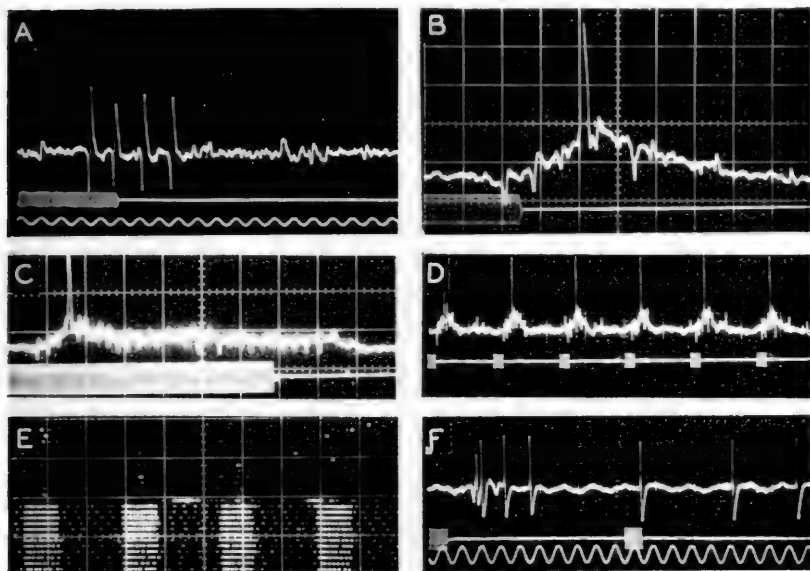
Responses to stimulation of the tympanic organ recorded with micro-electrode from sensory and interneurons in the pterothoracic ganglion of noctuid moths (*Caenurgina erechtea* and *Heliothis zea*). A. A_1 spikes recorded from neuropile in response to a 5-millisecond ultrasonic pulse (middle trace); time (lower trace), 1000 cycles per second. B. A_1 spikes (small downward deflections) and single pulse-marker spike (large upward deflection) in response to 5-millisecond sound pulse (lower trace). Time, 2 milliseconds per division. C. The same, response to a longer (38-millisecond) sound pulse. Time, 5 milliseconds per division. D. Single pulse-marker spike recurring in response to each of a series of short ultrasonic pulses (lower trace) repeated 40 times a second. E. Train-marker response. Spikes are indicated as dots on a raster that should be read like consecutive lines on a printed page. Groups of larger dots are A_1 spikes, and indicate parameters 2-5 of the stimulus. Smaller dots are train-marker spikes, recurring at a frequency independent of the pulse repetition rate throughout the stimulation period. F. Change in the pattern of spikes in the motor nerve supplying a muscle controlling extension of the forewing in response to stimulation of the tympanic organ (middle trace). Motor response begins about 20 milliseconds after first sound pulse reaches the ear. Second sound pulse appears to have no effect. Time, 100 cycles per second.
